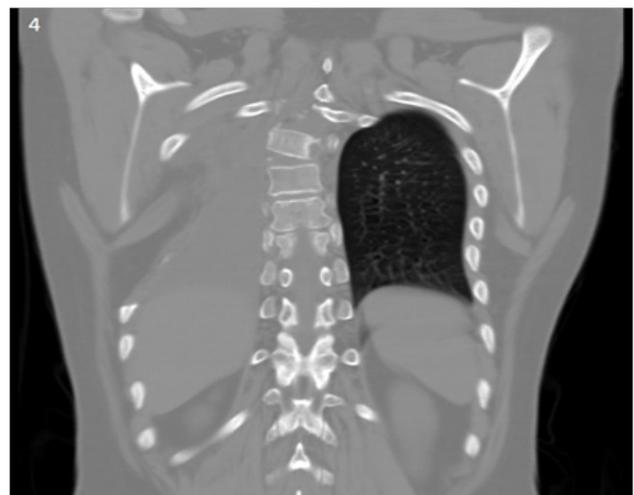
Thorax CT scan coronal view. Right pleural effusion and absence of 5, 6 and 7 right costal arcs.
